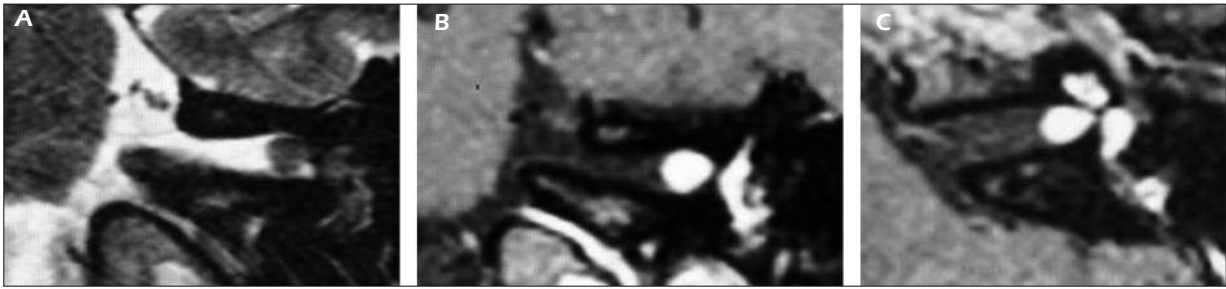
A-C, MRI coronal plane T1-W images: soft strongly enhancing tissue post contrast in the left internal auditory canal, indicative for VS.
